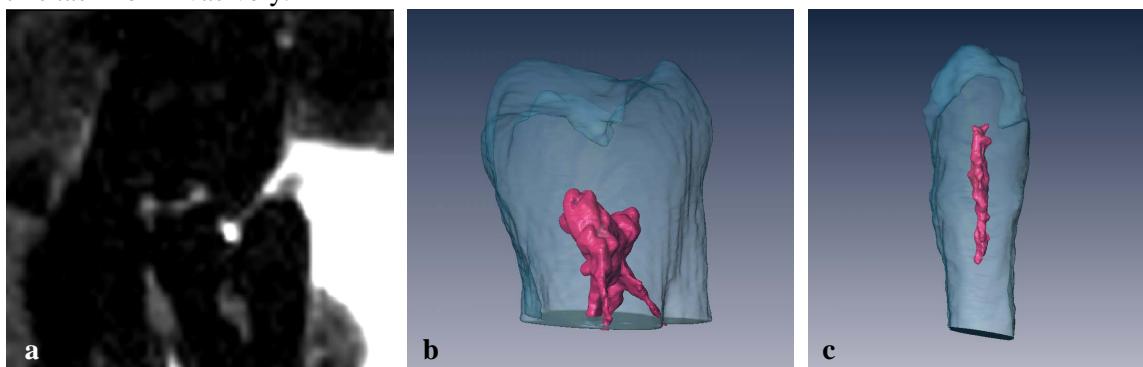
(a) Fragment of a slice from a 3D MRI dataset. 3D rendering of a molar (b) and premolar (c) with a carious lesion and of the tooth pulp based on MRI datasets.
